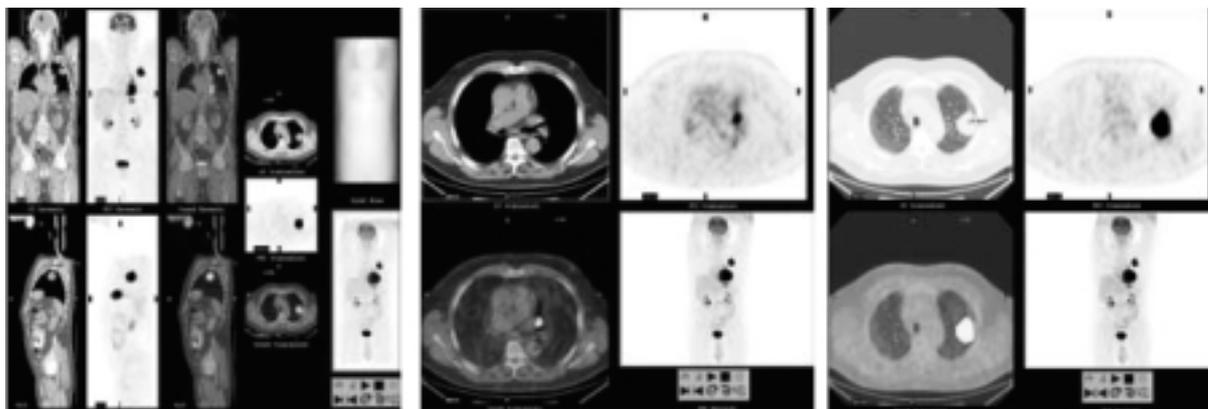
A 64-year-old man with a non-small-cell lung carcinoma (squamous cell carcinoma) of the left upper lobe with intrapulmonary lymph node metastasis. (A) Full computer screen with CT, PET, PET/CT scans and maximal intensity projection (MIP) showing the extent of disease. Physiological FDG uptake in the brain, myocardium, kidneys and bladder. No evidence of mediastinal or extrathoracic metastases. (B) Transaxial CT (pulmonary window), PET, and PET/CT scans showing the primary tumor which has contact with the pleura but does not invade the thoracic wall. (C) Transaxial CT (soft tissue window), PET, and PET/CT scans showing the ipsilateral peribronchial lymph node metastasis.
